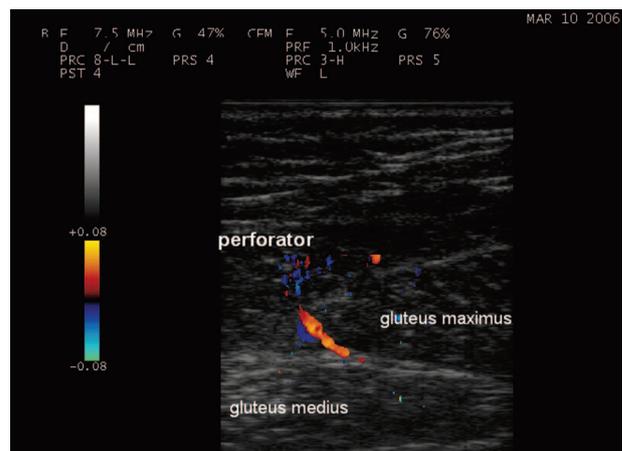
Color Doppler imaging of a septal perforator in a volunteer.
